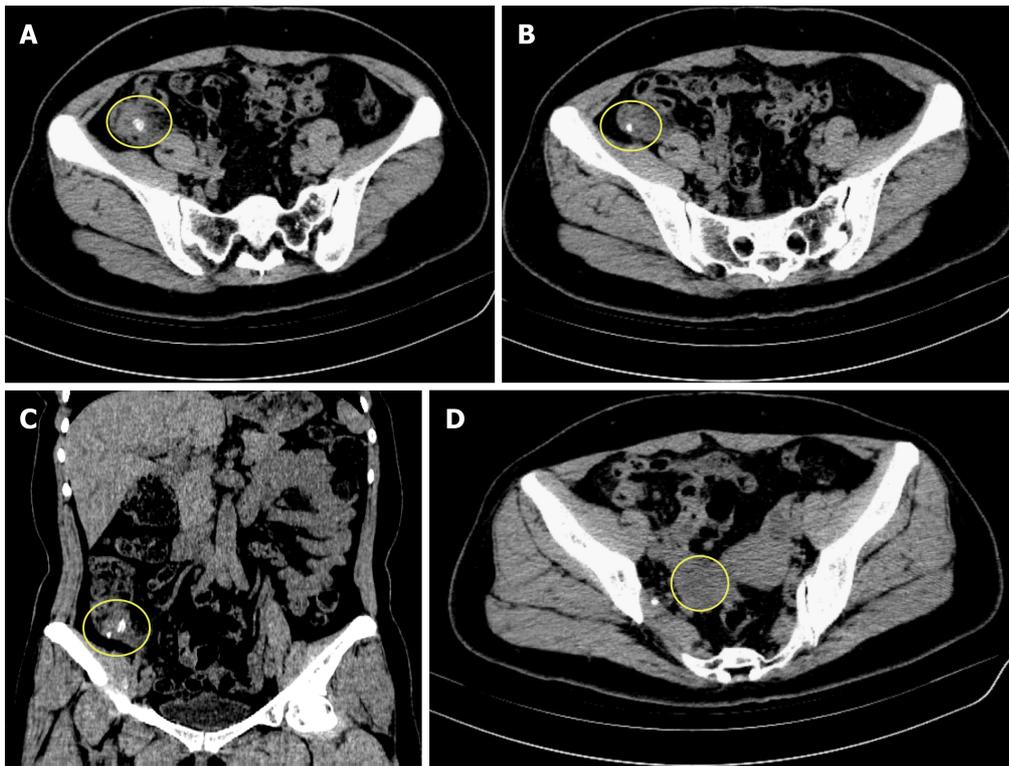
Computed tomography scan of the patient's abdomen. A and B: Transverse sections showing swelling of the appendix with surrounding exudation, and there is a fecalith at the root of the appendix, respectively; C: Coronal section showing swelling of the appendix with exudation and two separate fecaliths at its root; D: Transverse section showing a low density mass located in the right ovary.
